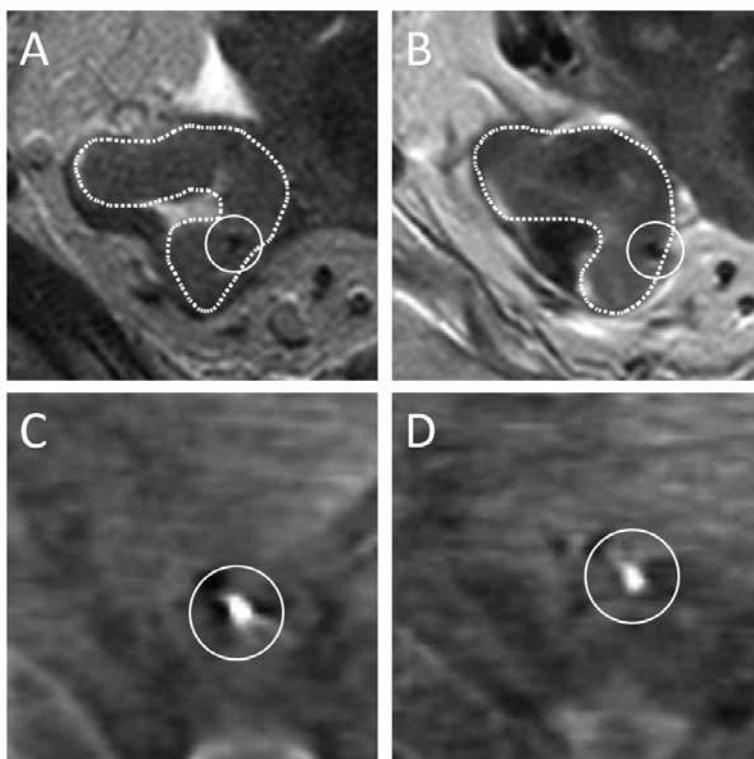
Examples of a GTV delineation and a fiducial on the T2-TSE sequence of both MRI exams (A and B) and the same fiducial on two pre-irradiation CBCT scans (C and D) for patient 19.
